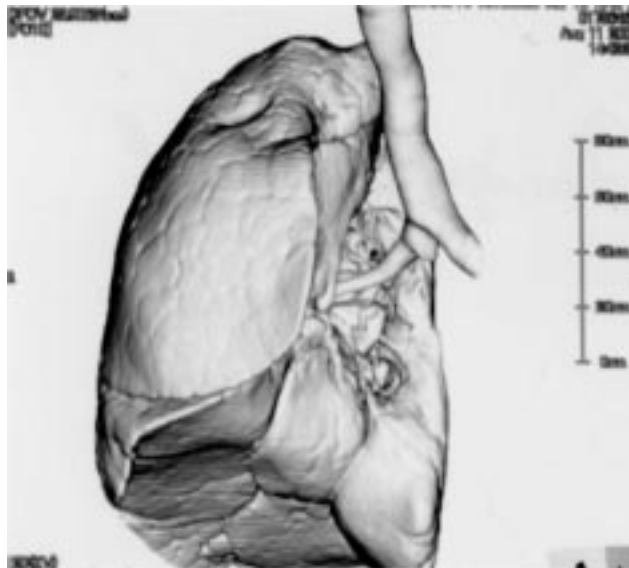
3D-CT showing no stenotic change and no kinking change in the anastomosis 4 weeks after the operation.
